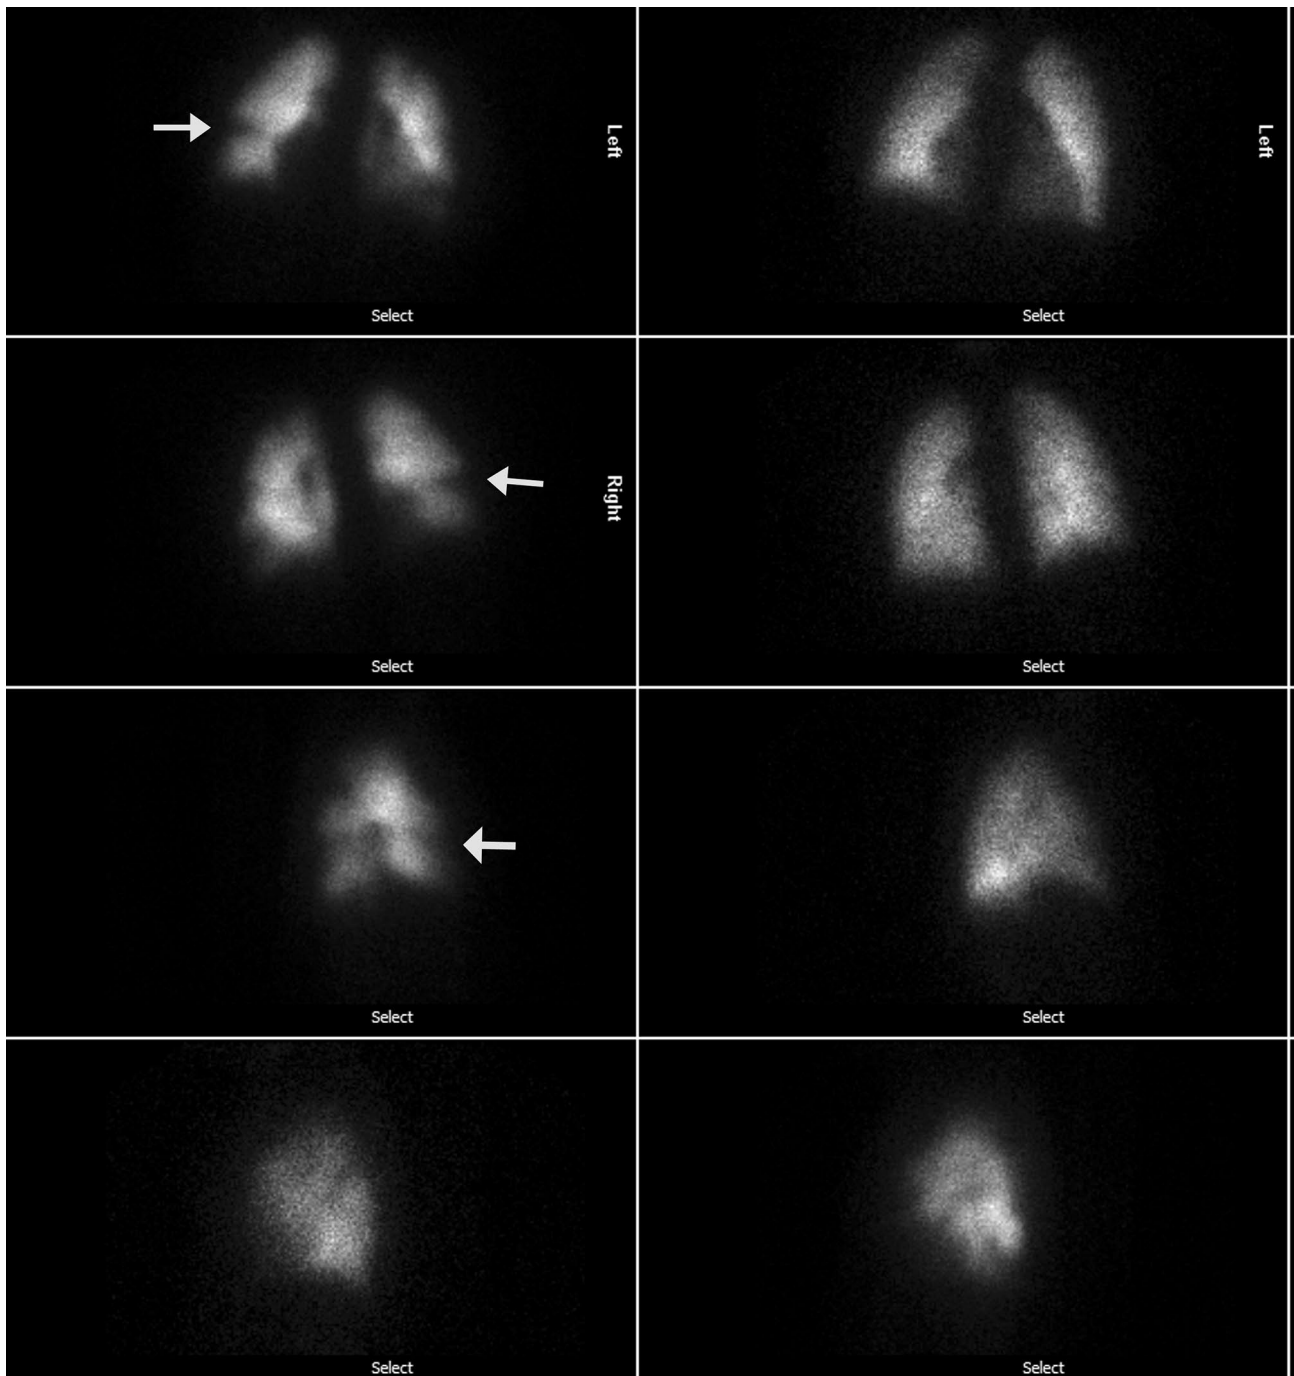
32-year-old woman with known CTEPH. V/Q scintigraphy with ventilation images on the right and perfusion images on the left demonstrate persistent defects bilaterally, most notable in the right lower lobe (arrows) which are mismatched on the ventilation scan
